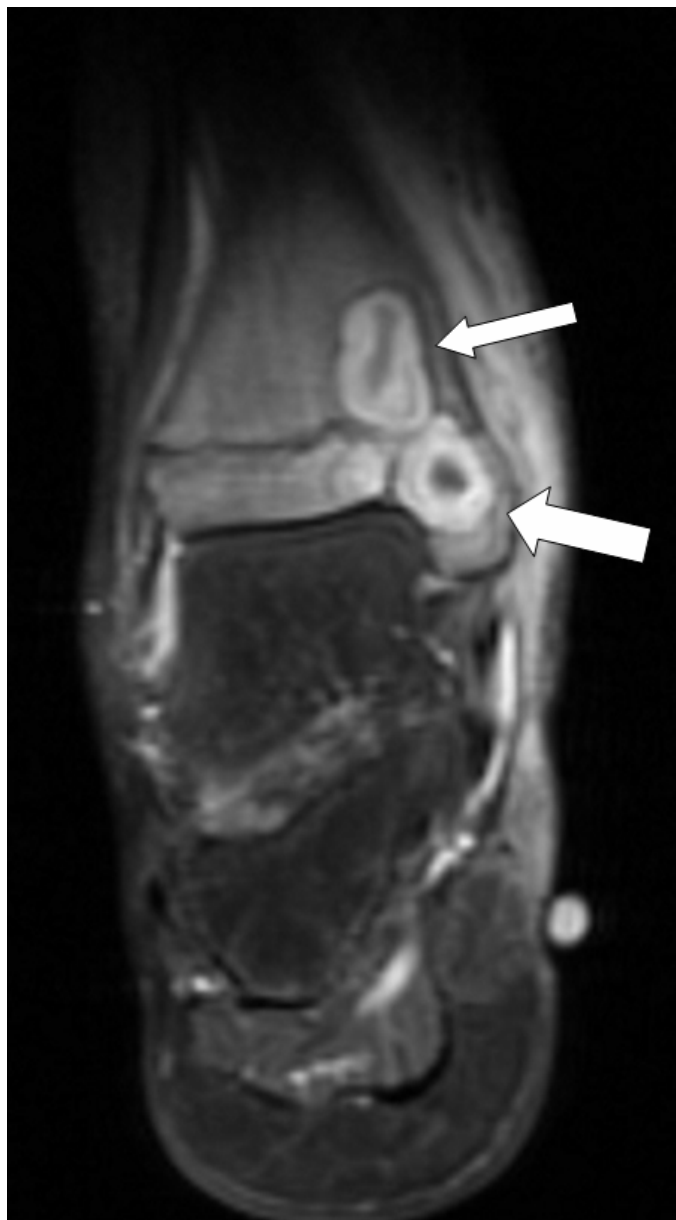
Coronal T1-weighted MR image after contrast shows well defined masses (arrows) with non-enhancing centers, enhancing thick rim, and non-enhancing periphery.
